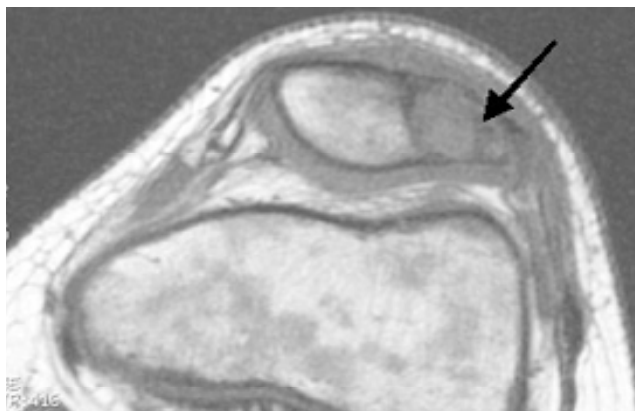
Magnetic resonance imaging scans of the left knee: (A) axial T₁-weighted and (B) T₂-weighted.
